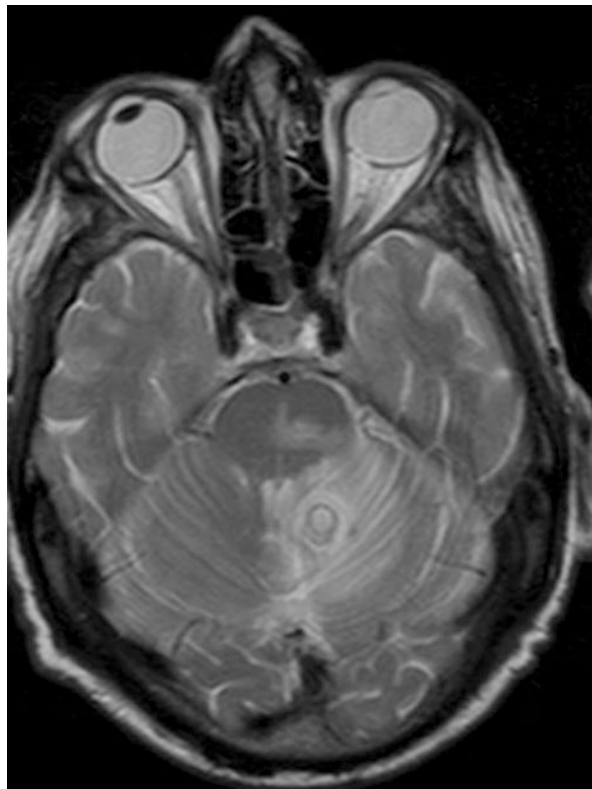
Magnetic resonance imaging (T2-weighted sequence) showing a ring-shaped cerebellar tuberculoma surrounded by edema. Another smaller tuberculoma was present in the pons (observe the presence of pons edema). Both disappeared with a four-drug antituberculous therapy for 1 year
